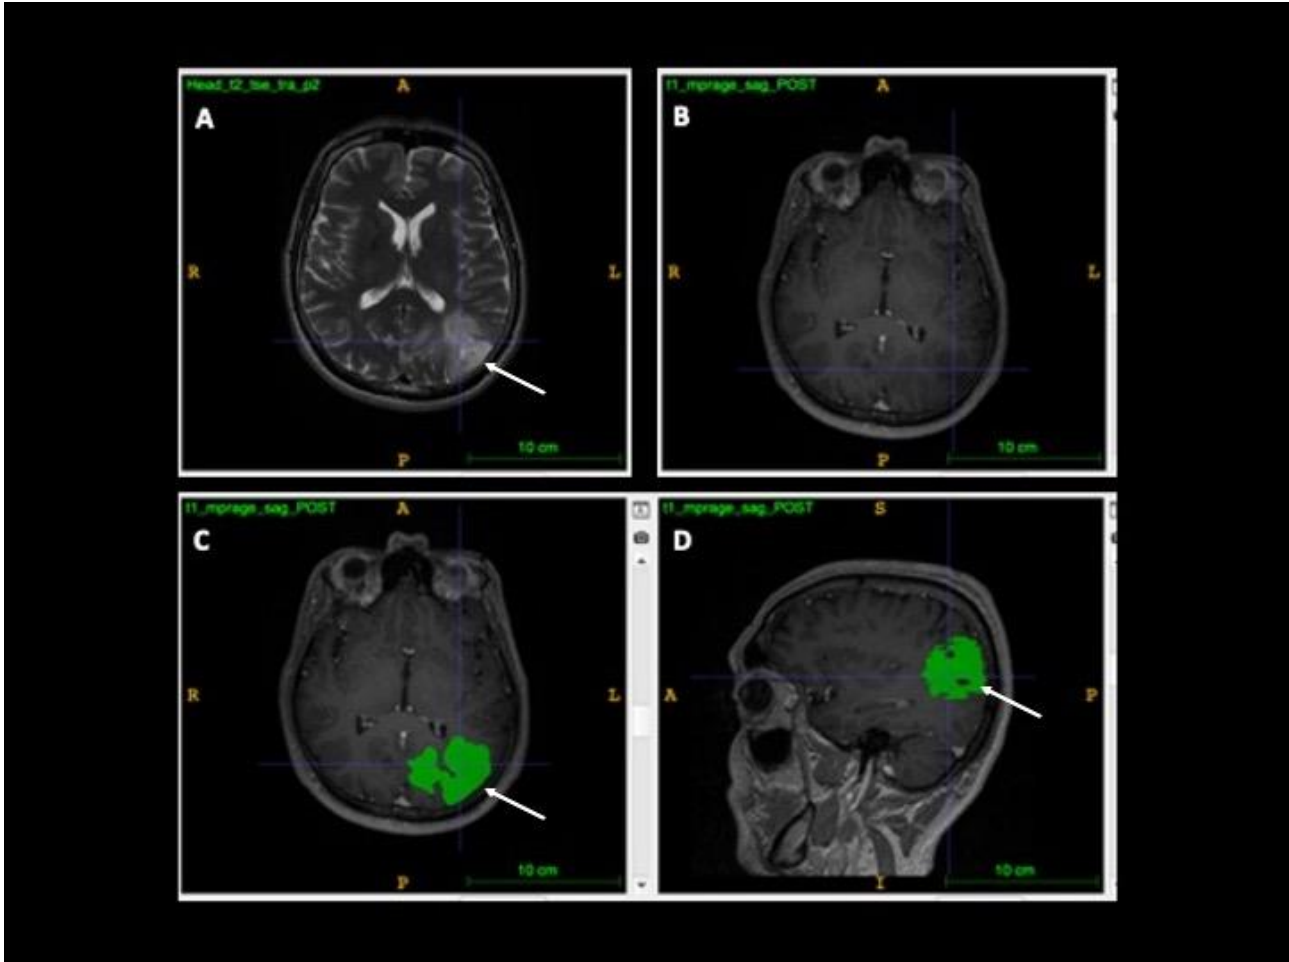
MRI demonstrating regions of interest in a 14-year-old male with pathologically proven diffuse astrocytoma. (A) T2-w axial image demonstrates a large area of T2-w signal abnormality in the left occipital lobe. (B) There is no associated pathological enhancement. (C) and (D) T1-w post-contrast images demonstrate the non-enhancing region of interest (green) in (C) axial and (D) para-sagittal planes.
